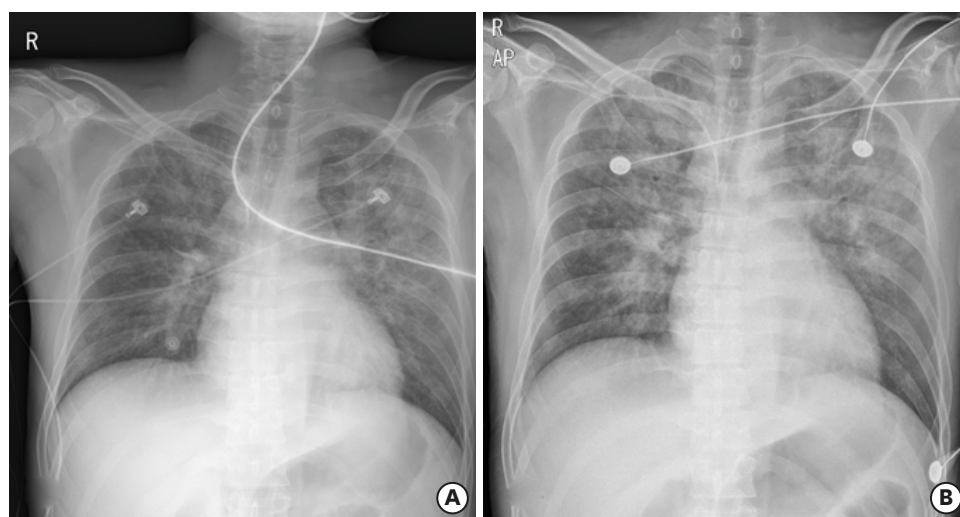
Simple chest radiography (A) in the morning of the day when the patient was referred to our hospital. (B) Bilateral diffuse opacities emerged in six hours, suggesting newly developed acute respiratory distress syndrome.
